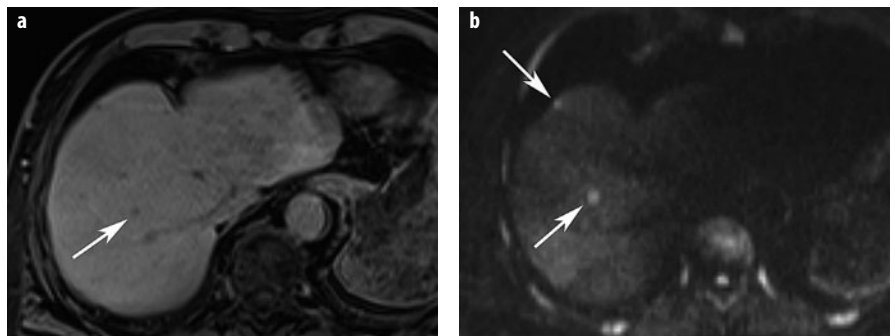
a-c. Colorectal liver metastases at gadoteric acid-enhanced MR imaging. a Unenhanced T1-weighted sequence shows two hypointense lesions in segments 6/7 and 4. b T2-weighted TSE pulse sequence shows the lesions to be moderately hyperintense. c Gadoteric-acid-enhanced T1-weighted GRE image in the hepatobiliary phase shows two additional small subcapsular metastases (*arrows*) not seen on unenhanced MR imaging or MDCT (not shown)
